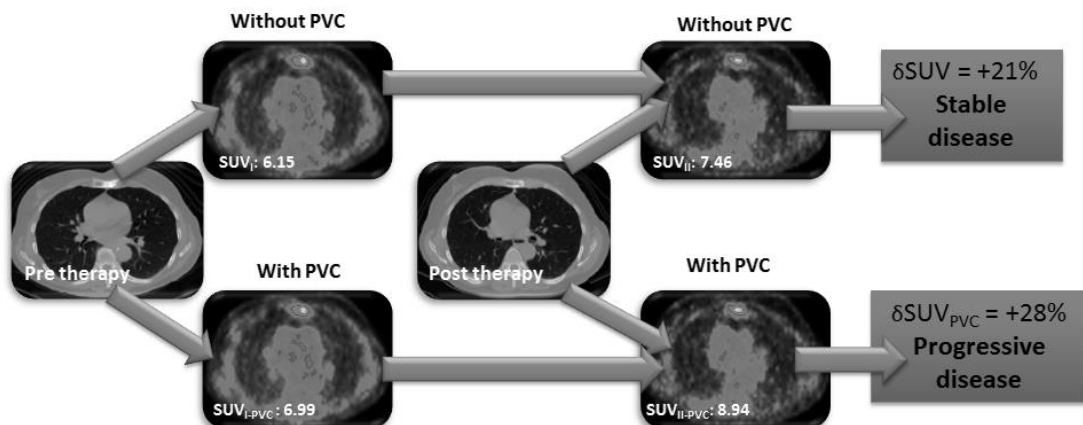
PVE has a critical impact on PET SUV treatment monitoring.
